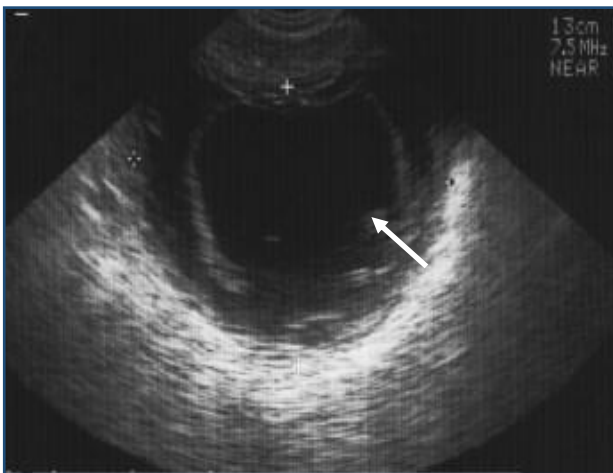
Ultrasonography of left ovarian hydatid cyst of size 15x12x8 cm
